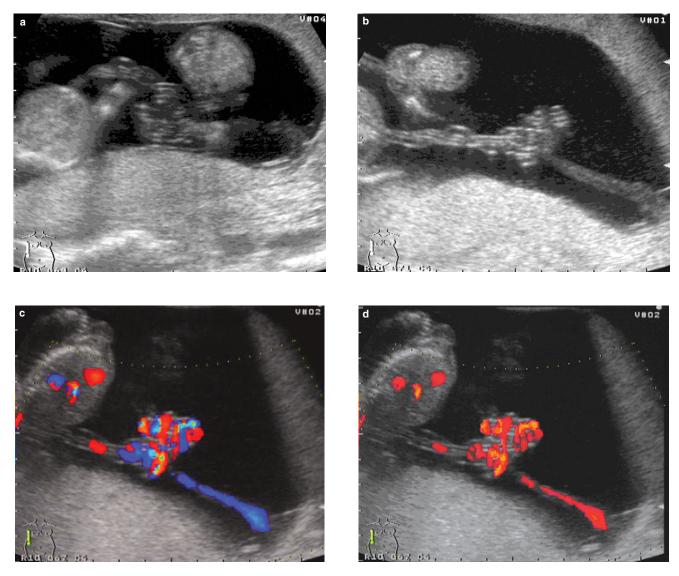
(a) Monoamniotic twins. A single amniotic cavity, a single placenta and two umbilical cords closely inserted are criteria for diagnosis of monoamnionicity. (b) 2D image of cord entanglement in monoamniotic twins. 2D sonography is unable to distinguish between adjacent and entangled umbilical cords. (c) 2D color Doppler imaging of umbilical cord entanglement. (d) 2D power Doppler reconstruction of umbilical cord entanglement
